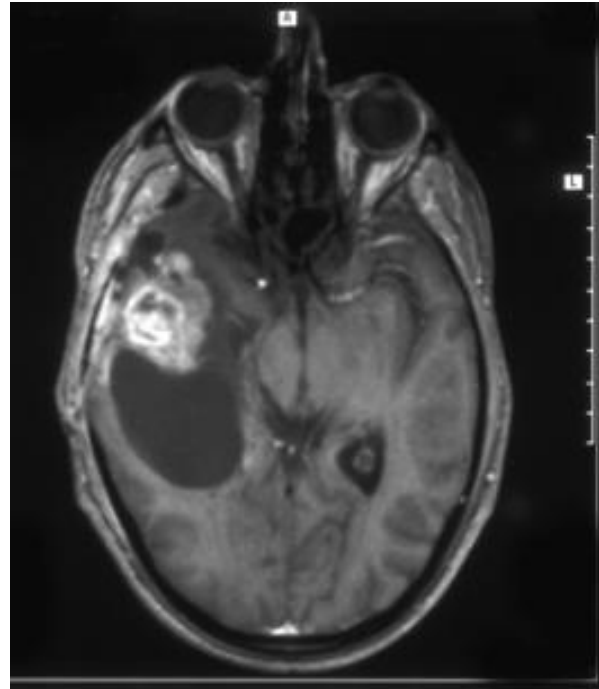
Magnetic resonance imaging (MRI) before third and last operation in 1999 showing tumor recurrence.
